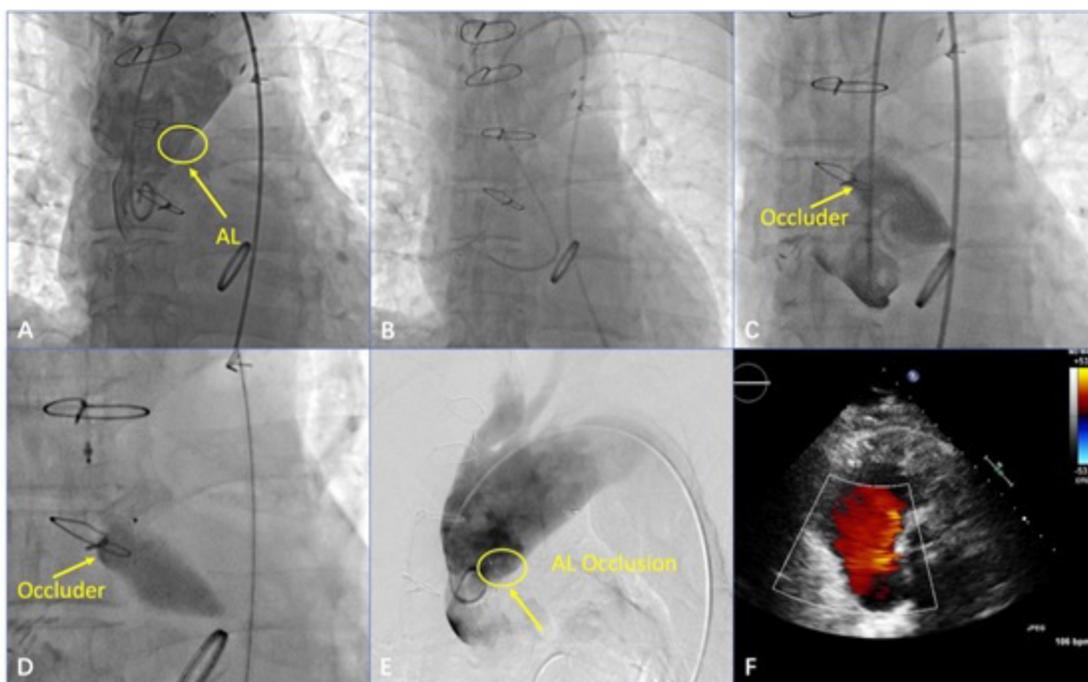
Intra- and postprocedural digital subtraction angiography images showing closure of the anastomotic leak. (A) Digital subtraction angiography showed the position of the anastomotic leak (arrow shows the anastomotic leak). (B) The catheters were exchanged after the guide wire went through the leak. (C) The position of the occluder was adjusted (arrow shows the occluder). (D) The occluder was released and could be seen clearly (arrow shows the occluder). (E) There was no regurgitation around the ascending aorta after the procedure (arrow shows the occlusion). (F) Transesophageal echocardiography suggested that the anastomotic leak almost disappeared.
